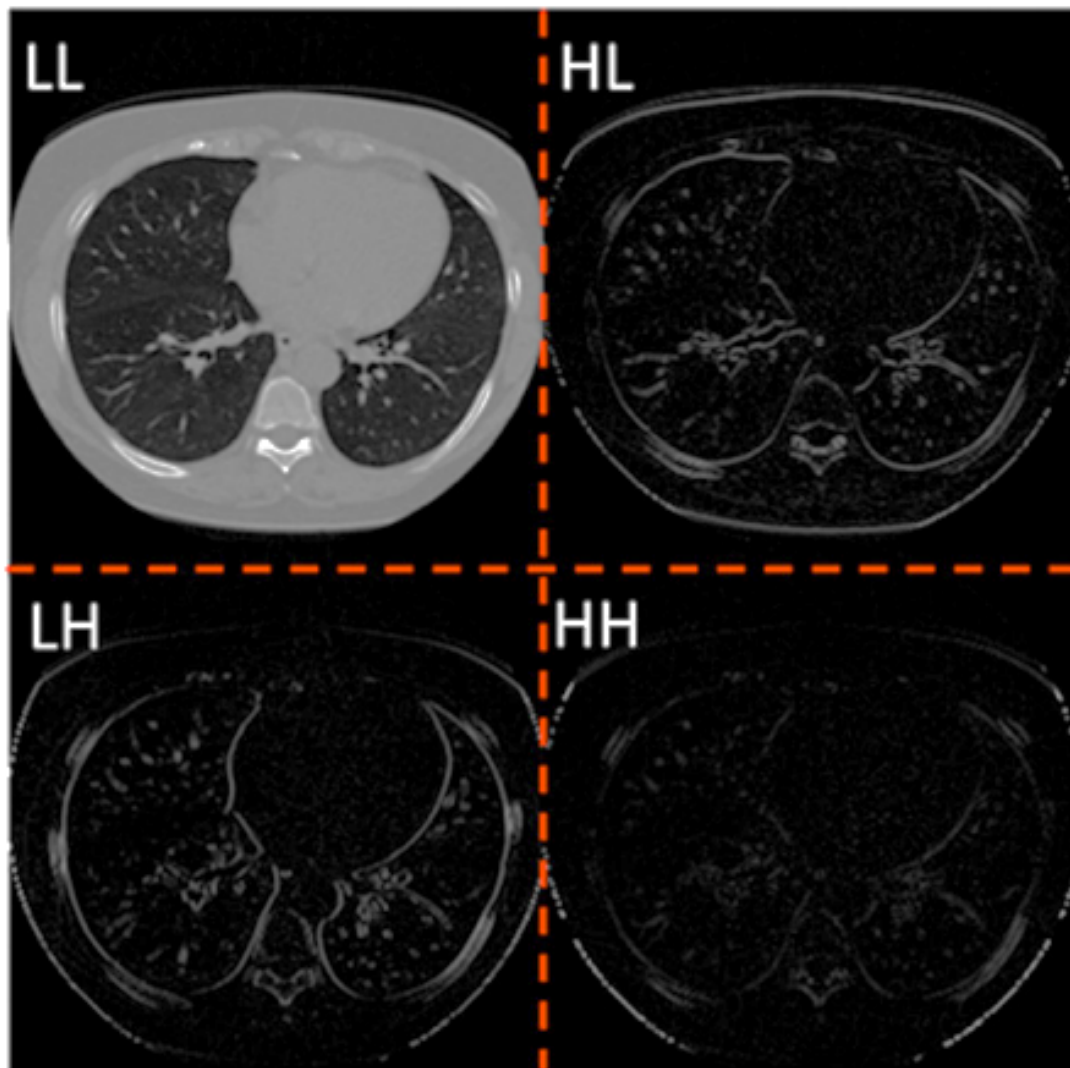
Wavelet decomposition of an axial slice from computed tomography scan. Four wavelet transformation of the original image using high- (H) and low- (L) frequency wavelet filters along the x and y axis. In this example of a patient with lung nodules, wavelet transformations may help to distinguish true nodules from normal parenchymatous injuries or other tissues. Reproduced with permission from Orozco M et al. *BioMedical Engineering OnLine* (2015) 14:9.*
